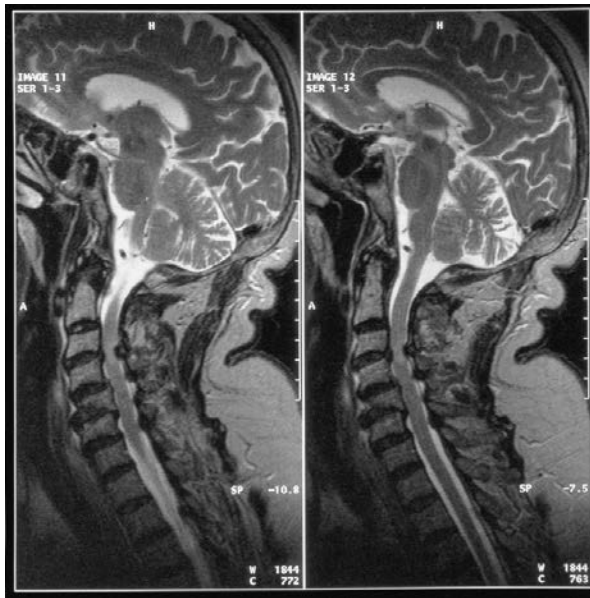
Magnetic resonance image of the cervical spinal cord in an 83-year-old woman with progressive sensory ataxia of the hands and a paraparesis showing multiple levels of spondylosis and marked canal stenosis at C3, 4, C4, 5 and C5, 6 with cord compression and distortion at these levels.
